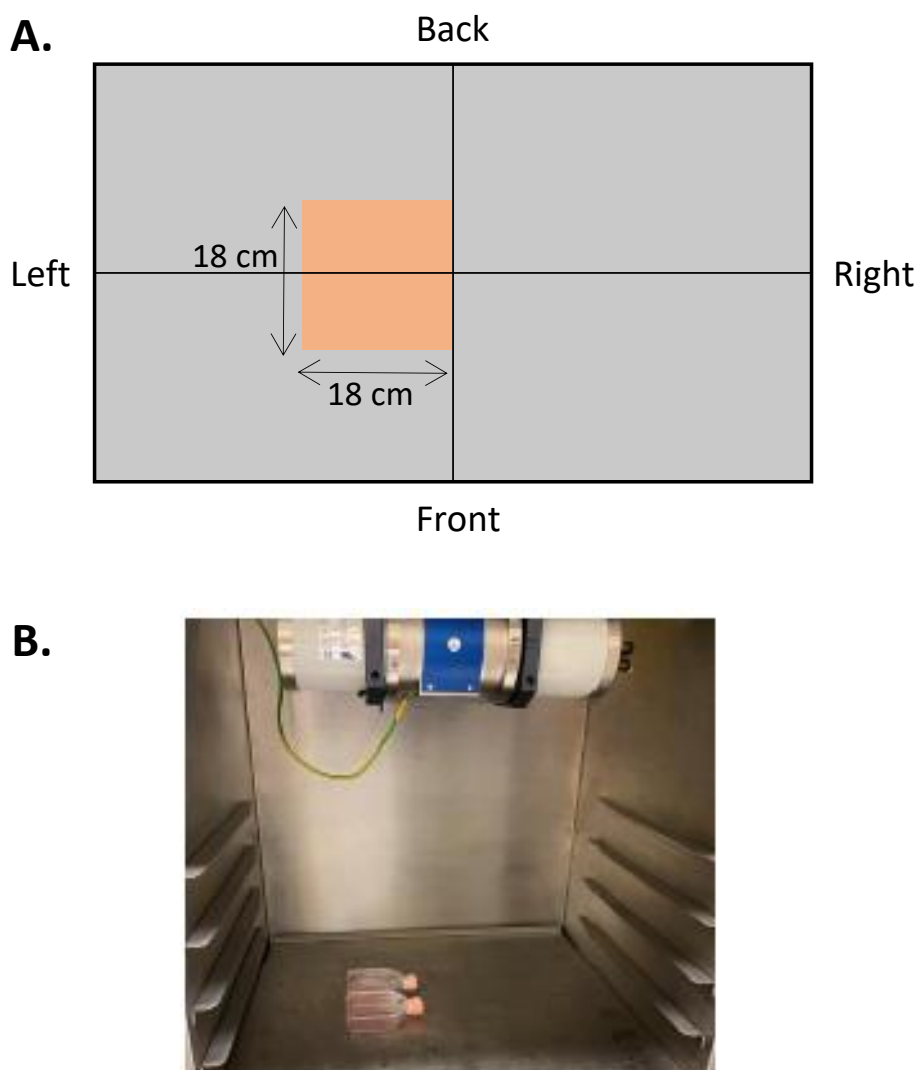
Inside the Gulmay RS320 X-Ray irradiator. A) The focal region (orange) of the irradiation field, B) Two 75cm² flasks were placed in the centre of the focal region for consistent irradiation.
